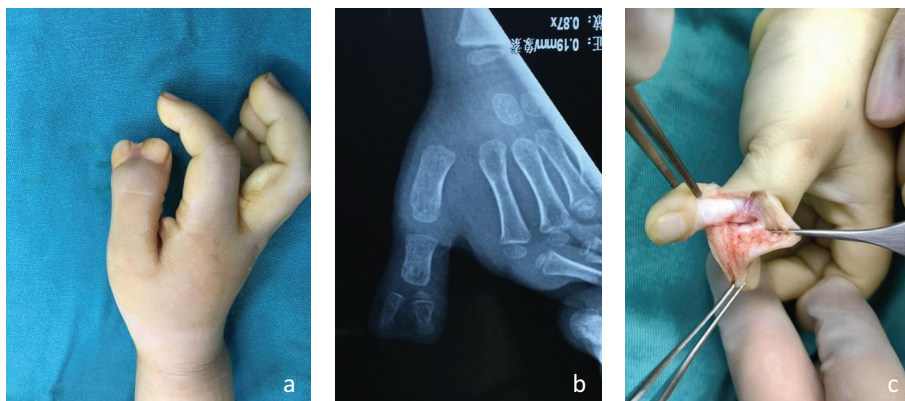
Reclassification of a case initially diagnosed as Wassel type II. (a, b) Clinical appearance and radiographs are consistent with Wassel type II thumb polydactyly. (c) Intraoperative findings confirmed Wassel type I, revealing a cartilaginous connection between the duplicated distal phalanges.
